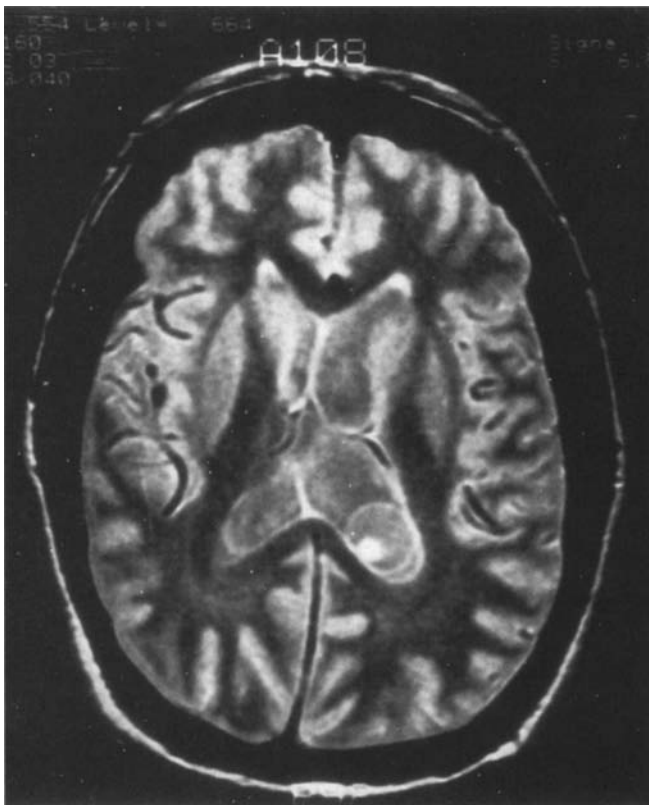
Axial proton-density MRI reveals an intraventricular cyst in the occipital horn of the left lateral ventricle of a 32-year-old man who presented with symptoms of increased intracranial pressure and meningeal signs. The sulci are visible in the cyst.
